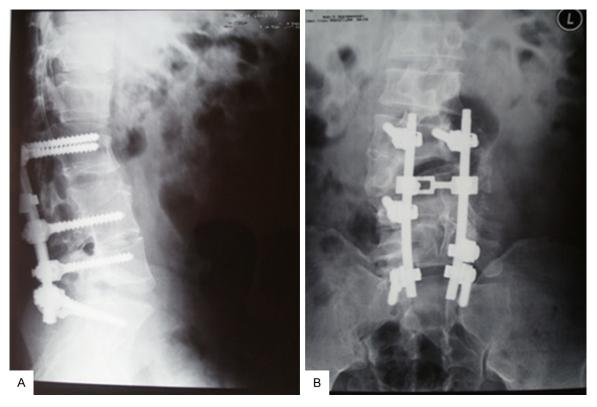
The result of postoperative X-ray. Postoperative X-ray shows that the L3-S1 implantation of 6 pedicle screws is accurate.
